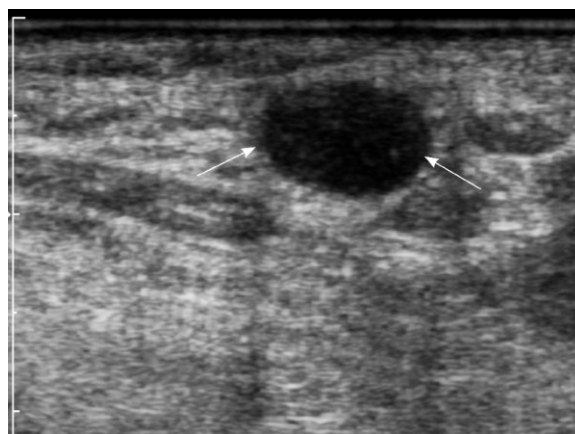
An ultrasound image of a lymph node (arrows) presenting in gray scale almost like a simple cyst: oval, anechoic, without the hilum, with posterior acoustic enhancement, in a 50-year-old male with a small lymphocytic lymphoma. The only sign suggesting possible solid nature of the lesion are very fine punctuate echoes inside.
